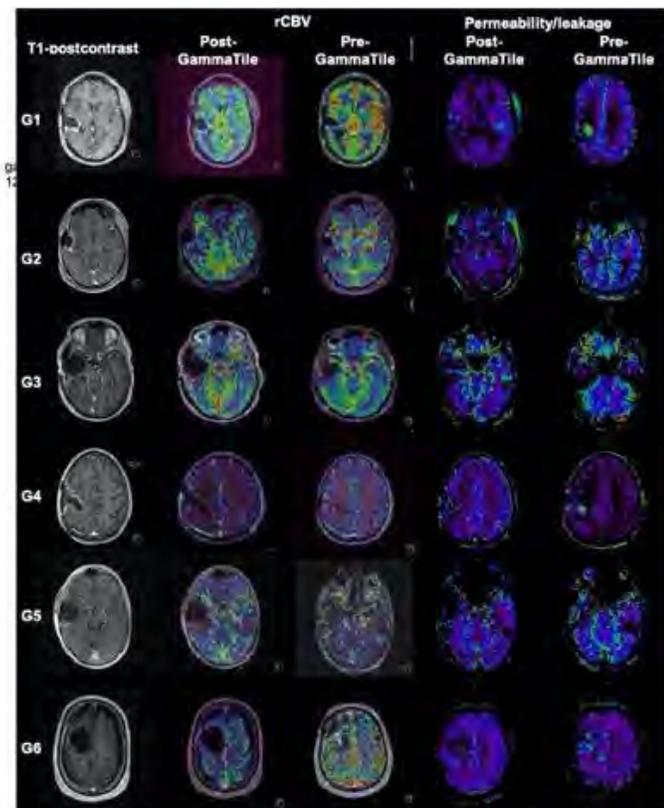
Axial MR post-contrast T1-weighted images of surgery and GammaTile placement, rCBV and permeability/leakage maps of post and pre GammaTile implants placement in 6 representative patients (G1-G6). There is significantly decreased rCBV at the margin of the resection cavity post-surgery and GammaTile placement in comparison with prior to the surgery. Perceivable decreased permeability/leakage at the margin of the resection cavity post surgery and GammaTile placement in comparison with prior to the surgery.
